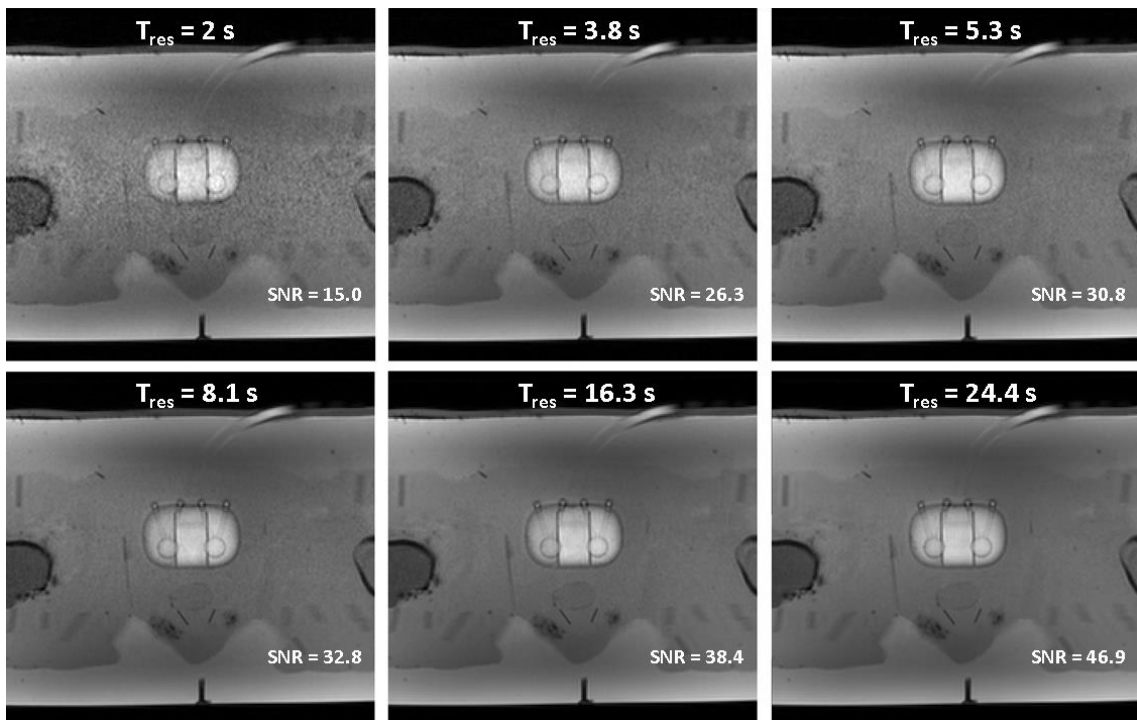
Representative images from approximately the same time-point within the dynamic series at the CTC peak (tumour) at each of the temporal resolution (T_{res}) values tested. SNR values derived from the DCE-MRI data are also presented. (SNR results presented herein should be treated as relative, for the purpose of highlighting relative behavioural trends in the data)
